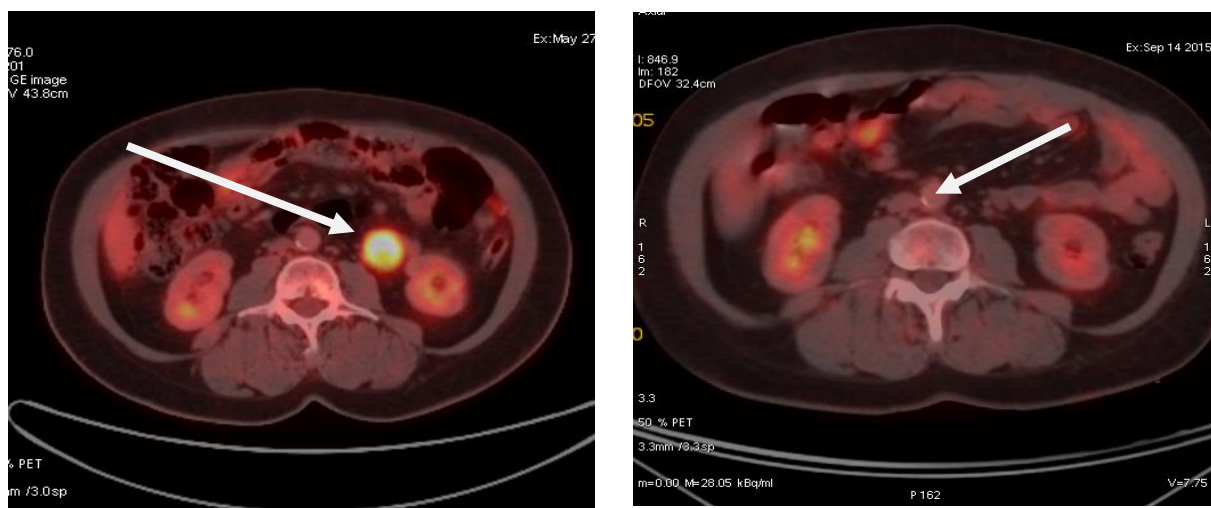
65 years old female patient with intestinal GIST on Imatinib mesylate. A baseline PET/CT (the right image) shows multiple peritoneal deposits. Follow up PET/CT (the left image): showed complete metabolic remission (CMR).
